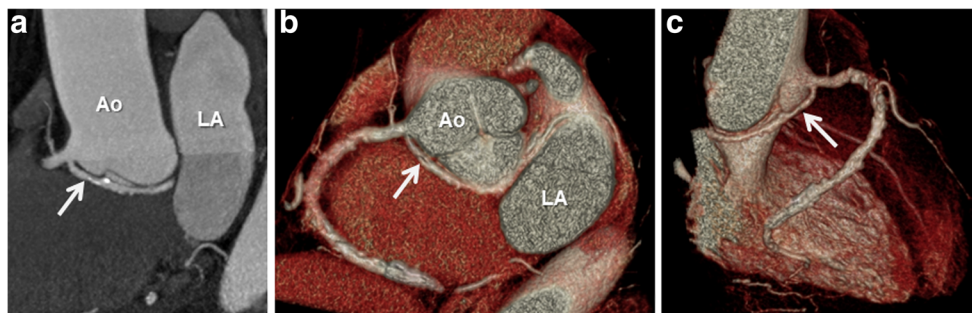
A 54-year-old male with multiple medical problems presented with intermittent, non-exertional chest pain and underwent coronary CTA. a A multiplanar reformatted thin maximum intensity projection image demonstrates the anomalous origin of the left circumflex (arrow) from the proximal right coronary artery with evidence of calcified
